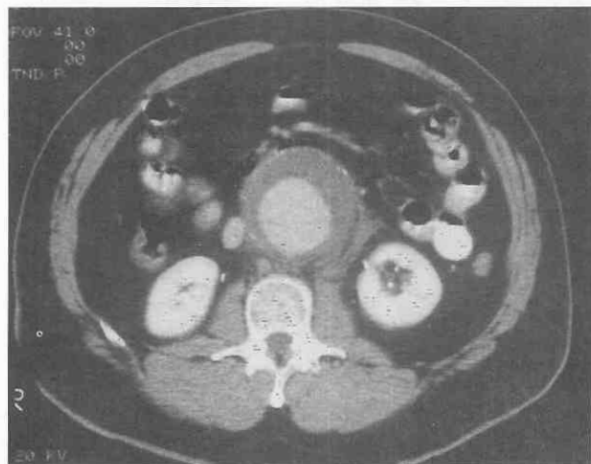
Ruptured abdominal aortic aneurysm. A small "contained" rupture is visualized along the left posterolateral aspect of this aneurysm on this contrast-enhanced CT image.
